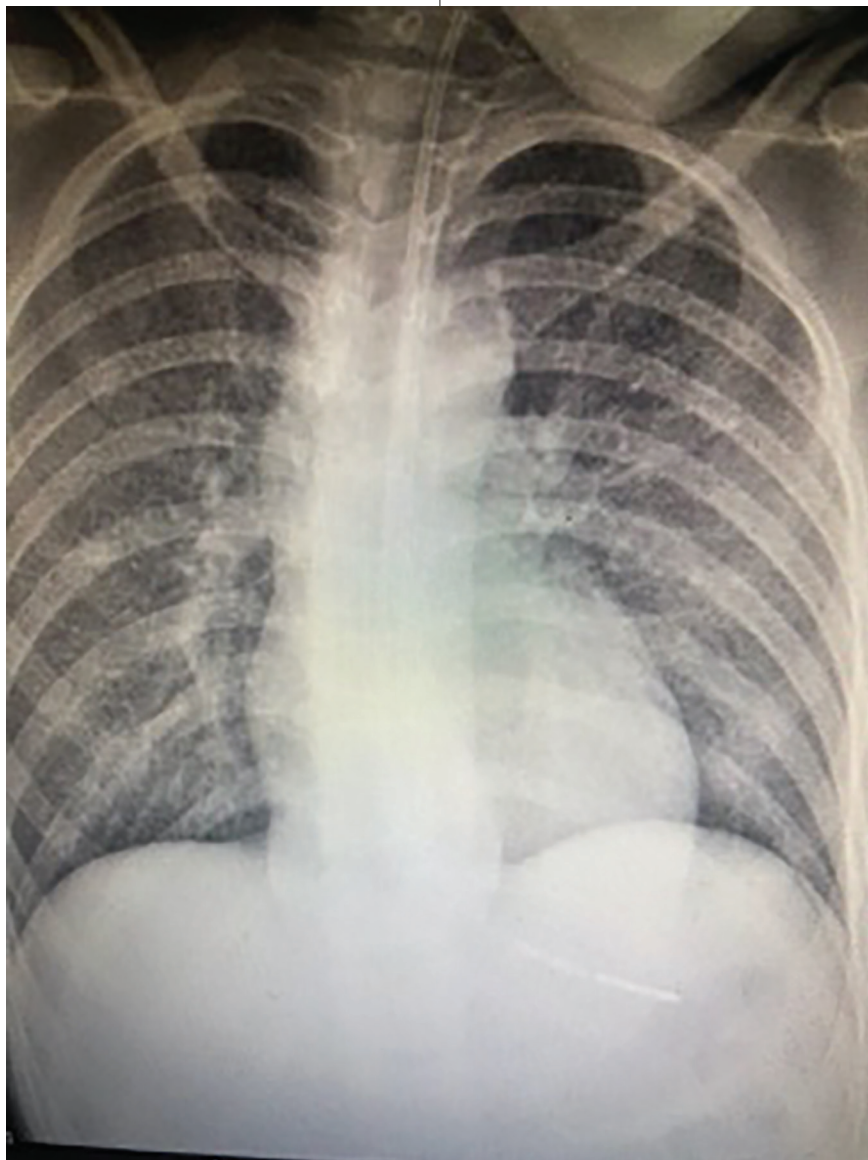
Chest radiograph showed nasogastric tube and thoracic mass.
